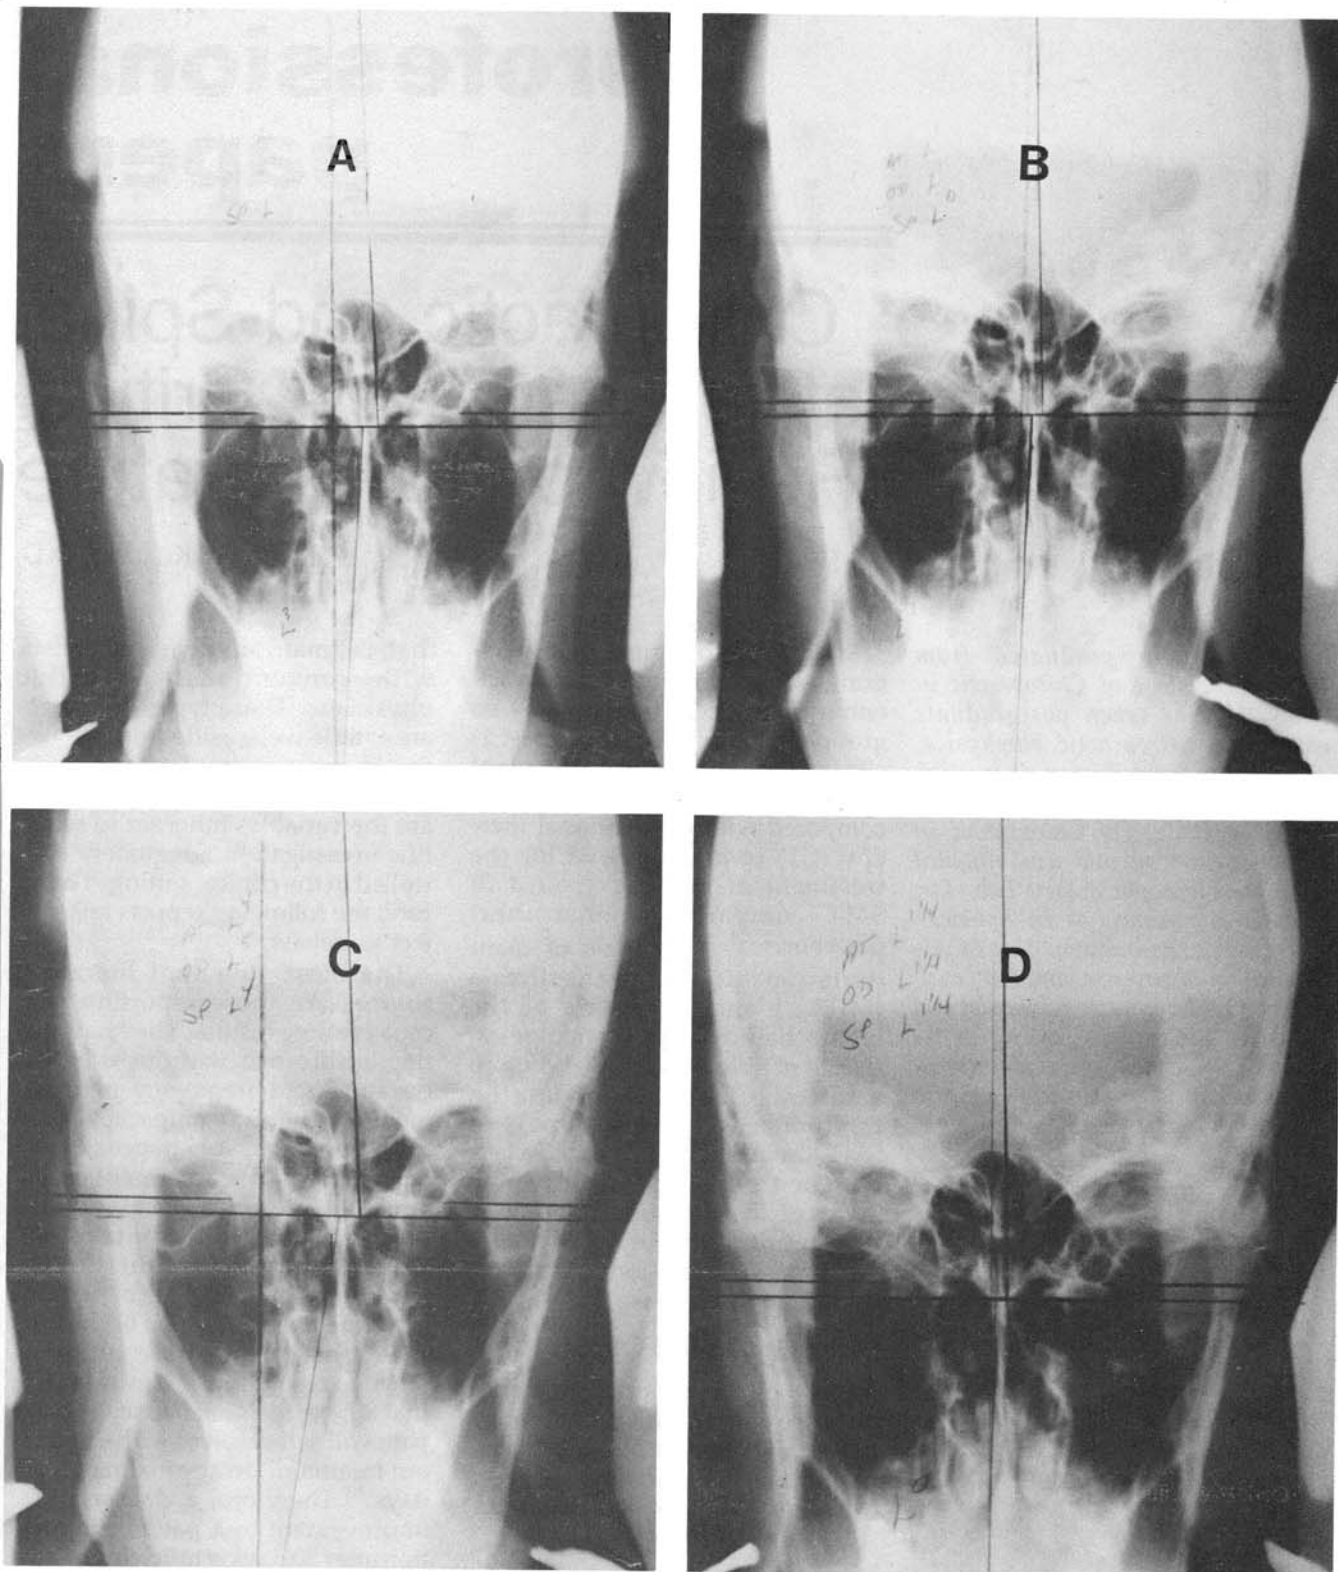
Radiographs demonstrating differing effects of a NUCCA-style and a Maitland or diversified-style manipulation on the static alignment of the cervical spine. A = Initial misalignment before manipulation of the patient's cervical spine. B = Radiograph taken immediately following a NUCCA-style adjustment demonstrating reduction of misalignment of the cervical spine. C = The same patient following a diversified or Maitland manipulation (as practiced by physical therapists). Note the exacerbation of misalignment. D = Patient's cervical spine is restored to more normal alignment following second NUCCA-style adjustment. (Radiographs courtesy of Dr. Glen Cripe, New Port Beach, California.)
